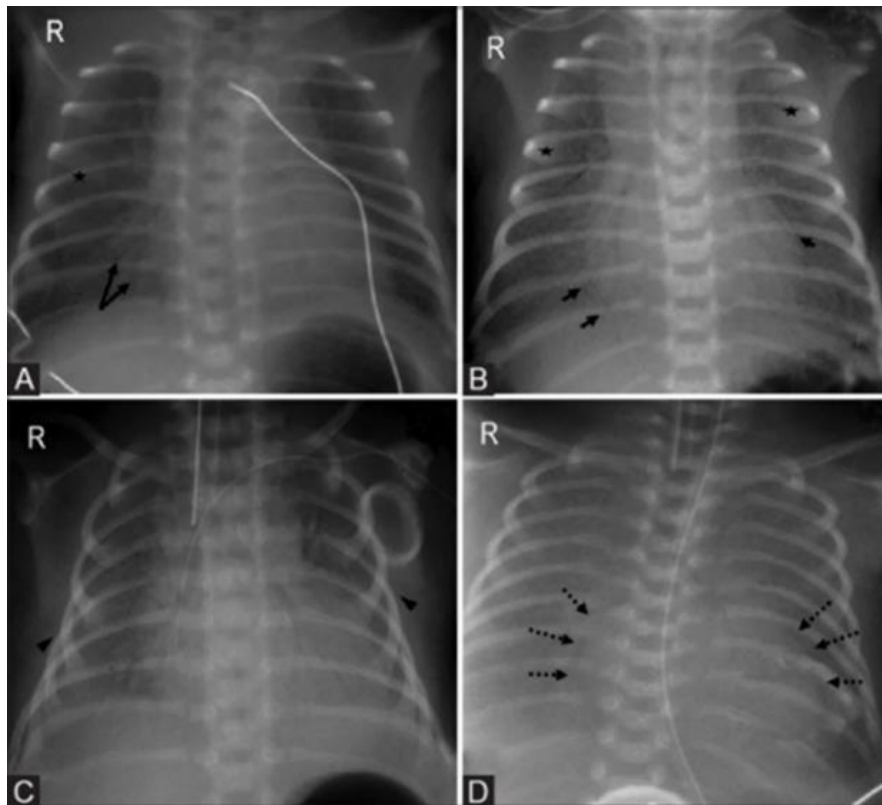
Progression of radiographic findings in respiratory distress syndrome [5].
